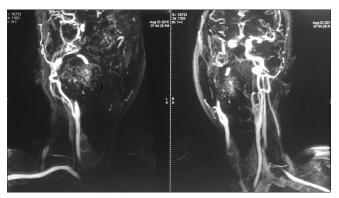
Computed tomography angiogram: Mass was not invading the vascular structures
